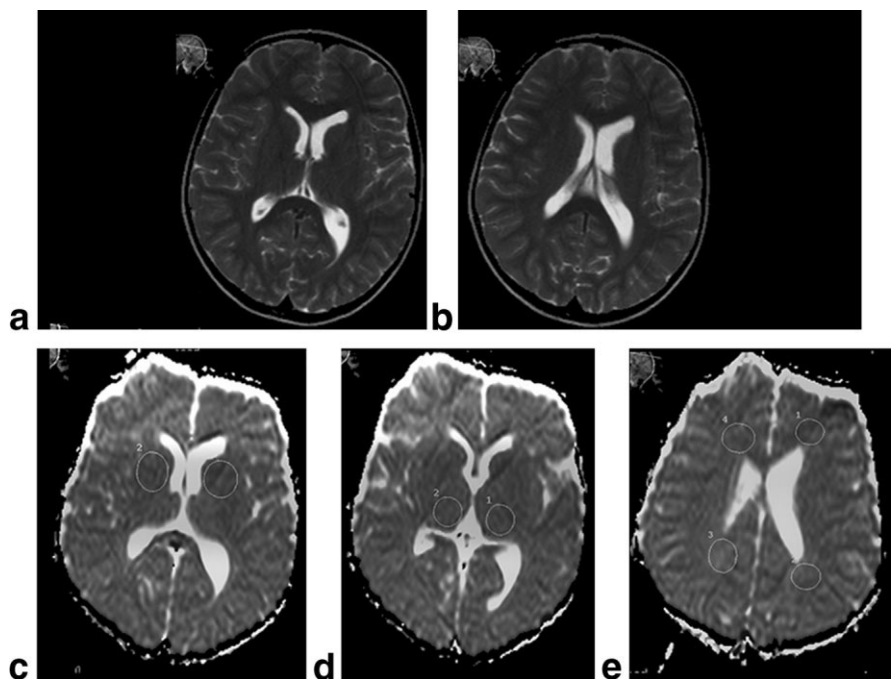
Findings in a 9-year-old girl with stage II SSPE. a and b: Axial T2-weighted image (TR = 4530 msec, TE = 100 msec) shows normal signal intensity in the periventricular white matter, basal ganglia, and thalamus. c-e: ADC maps reveal high ADC values in the basal ganglia (873 and $877 \times 10^{-6} \text{mm}^2/\text{sec}$), thalamus (838 and $841 \times 10^{-6} \text{mm}^2/\text{sec}$), and periventricular white matter (871 , 900 , 912 , and $924 \times 10^{-6} \text{mm}^2/\text{sec}$, respectively).
